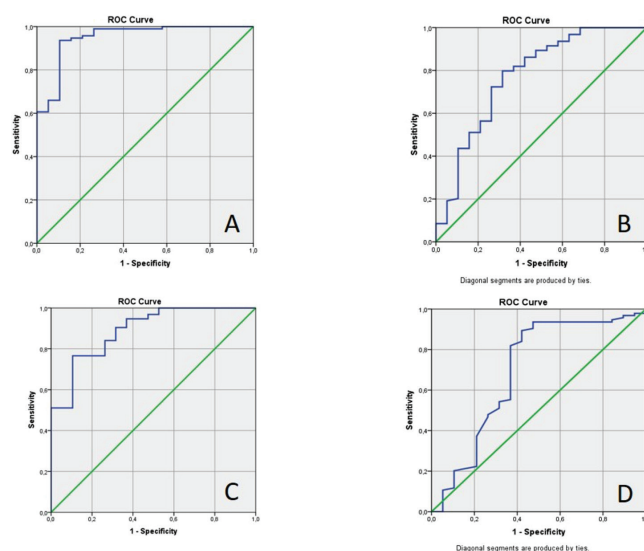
ROC analysis of SUV_{max} (A), metabolic tumor volume (B), total lesion glycolysis (C), and density (D) for malignancy
